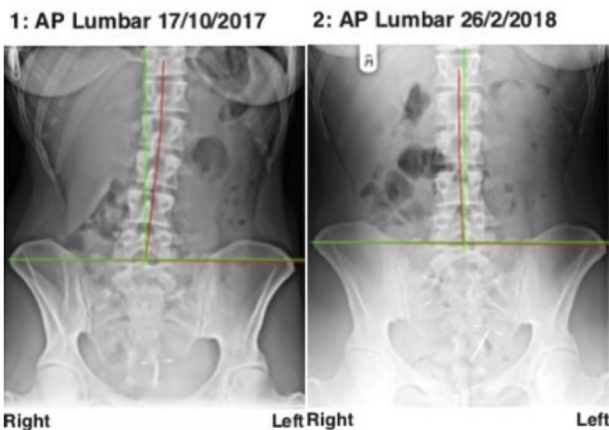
Anteroposterior lumbar radiographs. Left: Initial (10/17/17) demonstrating a 20.3 mm left lateral thoracic translation 'pseudoscoliosis' posture; Right: Follow-up (2/25/18) demonstrating complete reduction of deformity.
